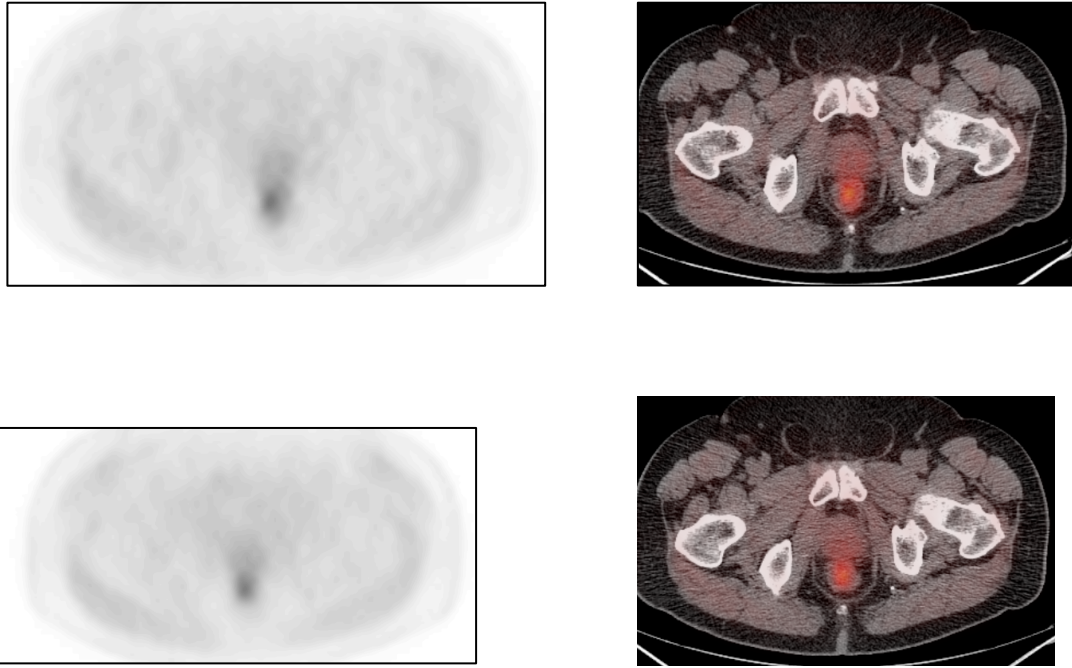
Axial PET and fused ^{18}F -FECH PET/CT images (Top row 60 minutes and bottom row 90 minute images) in a 58 years old patient , PSA 3.36 and previous history of radiotherapy showing no evidence of tracer avid disease. There was no evidence of malignancy on biopsy.
